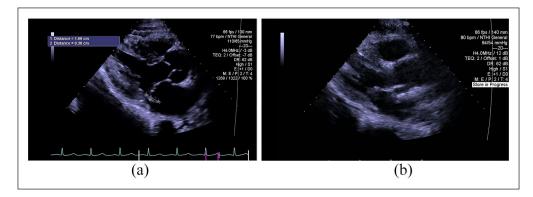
Parasternal long axis view of the echocardiogram showing (a) vegetation on the mitral valve and (b) clearance of the vegetation.
